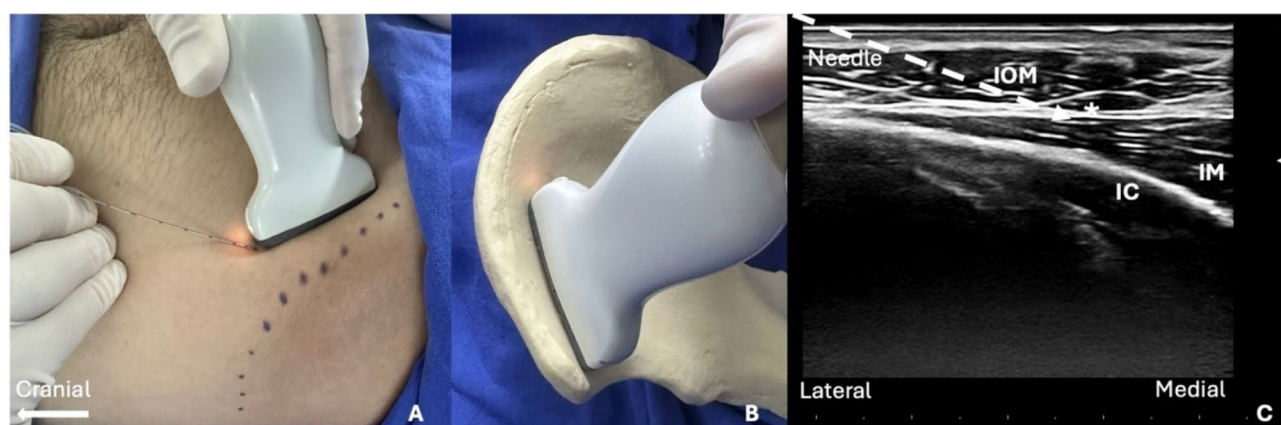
Anterior iliac block. A: Probe and needle position. B: The demonstration of probe position on a model. C: Ultrasound image, IC: iliac crest, IM: iliacus muscle, IOM: internal oblique muscle, *: aponeurosis of transversus abdominis muscle
